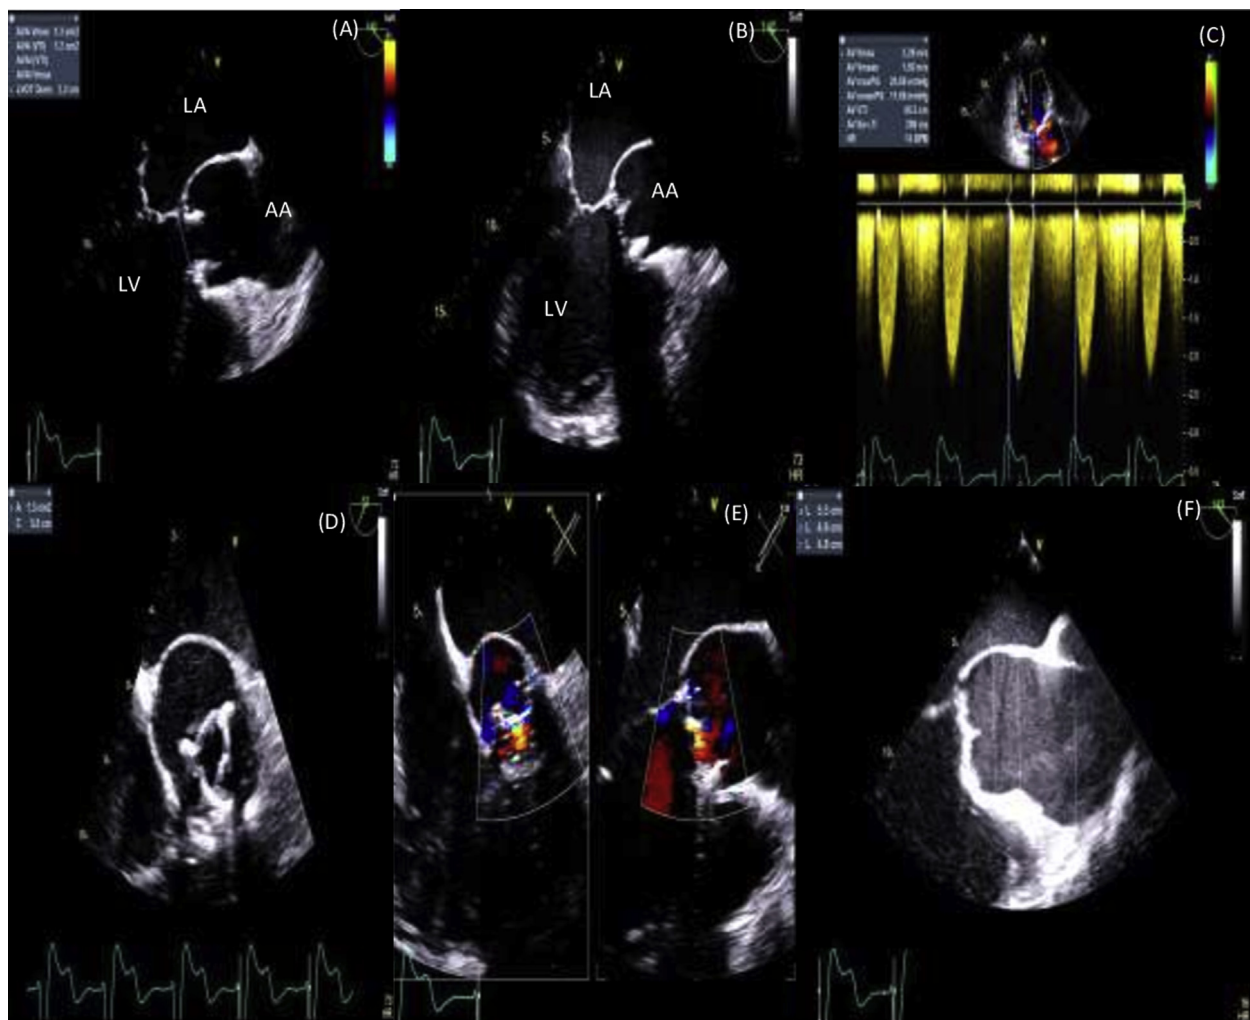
Transesophageal echocardiography performed in 2018 showing thickened valve leaflets but without major restricted prosthetic valve opening (A) and closure (B). The prosthetic valve effective orifice area is calculated at 1.2 cm² using the continuity equation method (A). Continuous-wave Doppler across the bioprosthesis showing peak and mean gradients of, respectively, 20 and 11 mm Hg at a heart rate of 74 beats/min (C). The prosthetic valve geometric orifice area is measured at 1.3 cm² by planimetry (D). Mild to moderate intraprosthetic regurgitation at diastole (E). Root and AA aneurysms measured at 48 and 53 mm, respectively (F). LA, Left atrium; LV, left ventricle.
